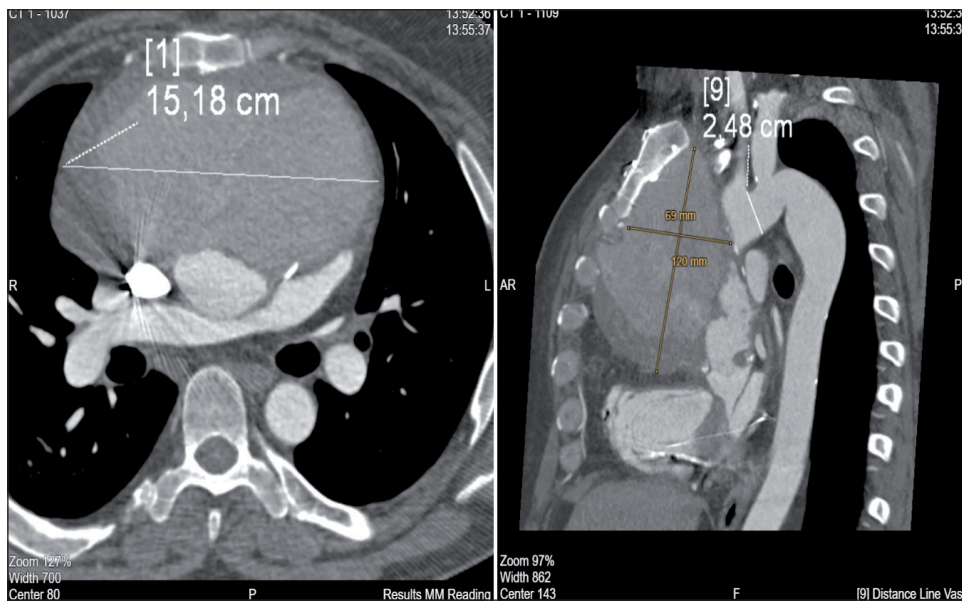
Chest CT scan before surgery.
